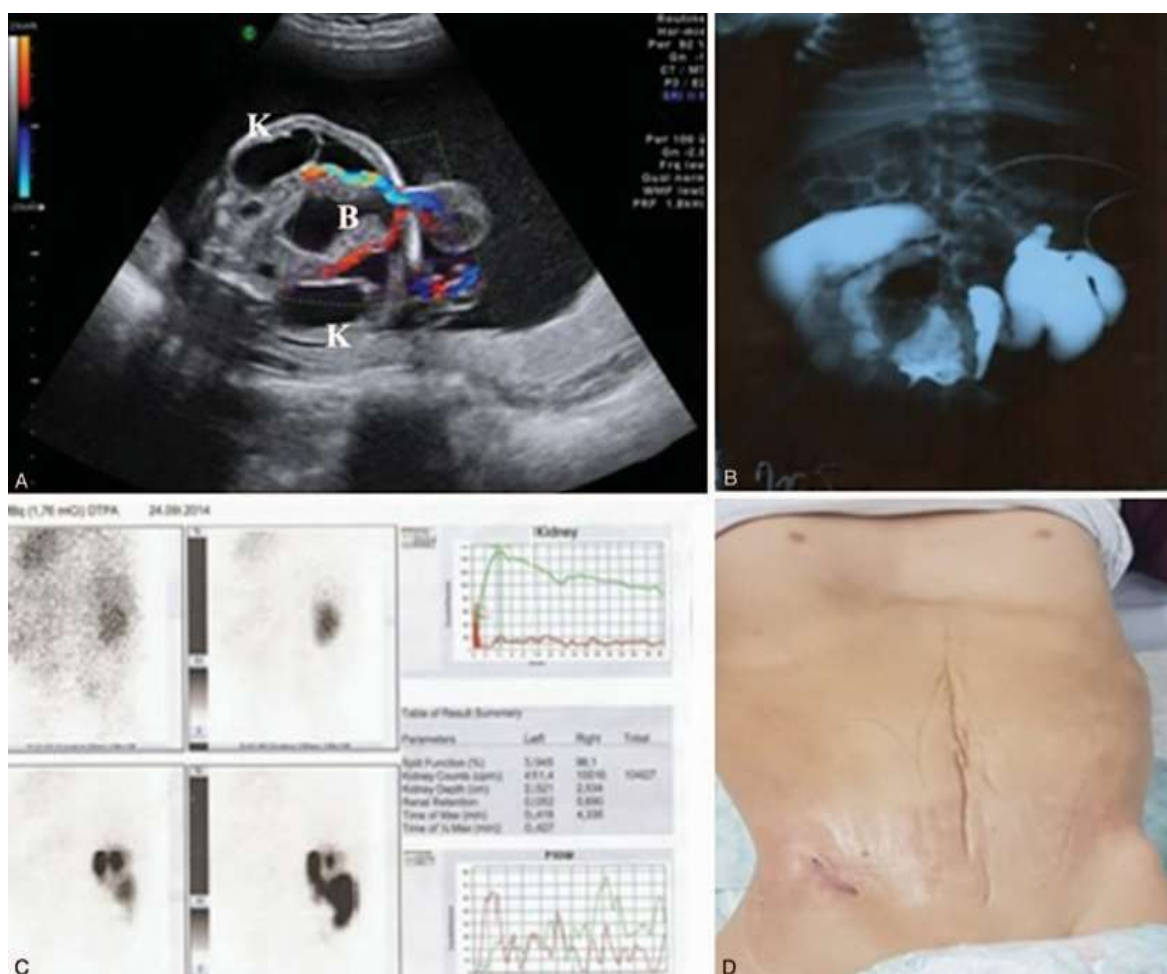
A. Prenatal ultrasonography showing an enlarged bladder (B), dilated ureters and hydronephrosis, kidneys with reduced parenchymal thickness (K); B. Voiding cystography: contrast agent introduced through the uracha into the bladder showing high degree bilateral vesicoureteral reflux (IV grade); C. Dynamic renal scintigraphy ^{99m}Tc -DTPA showing no glomerular function on the left side, the right side: no obstruction but with significant pooling in the right ureter; D. Photo of the patient at age of 10 showing the abdominal wall defect and right iliac fossa ureterostomy opening.
